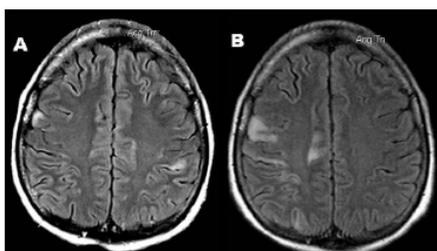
Patient 1: Sequential axial brain MRI T2 FLAIR images 2 weeks apart showing contiguous extension of the left frontal hyperintense lesion.
